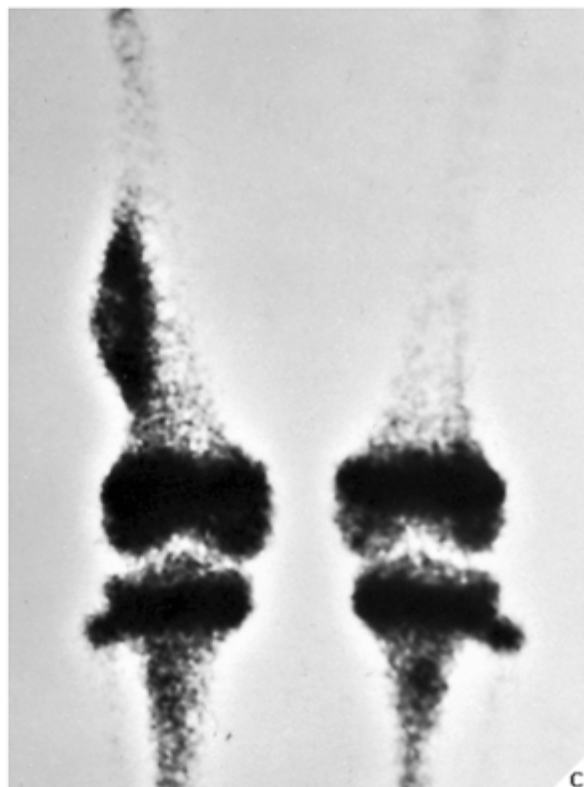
Aneurysmal bone cyst. Anteroposterior (A) and lateral (B) radiographs of the lower leg in an 8-year-old girl with a history of lower leg pain demonstrate an expansive radiolucent lesion in the metaphysis of the distal tibia, extending into the diaphysis. Note its eccentric location in the bone and the buttress of periosteal response at the proximal aspect of the lesion. Biopsy revealed an aneurysmal bone cyst.
